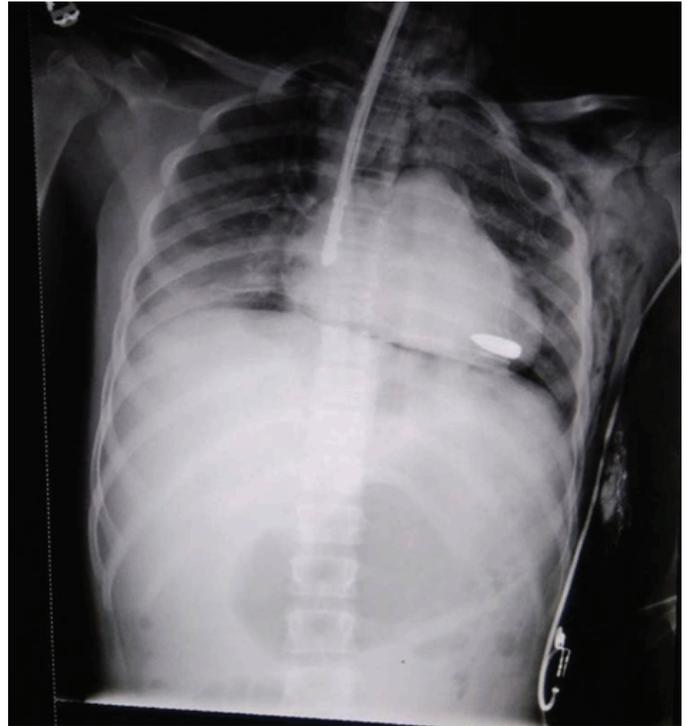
Plain chest X-ray showing bullet overlapping left cardiac shadow.
